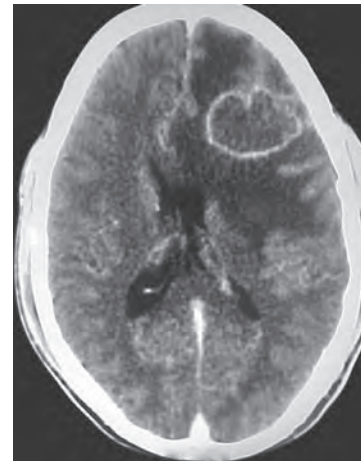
CT scan of left frontal tubercular abscess—a unilocular hypodense lesion with a thin rim of enhancement
